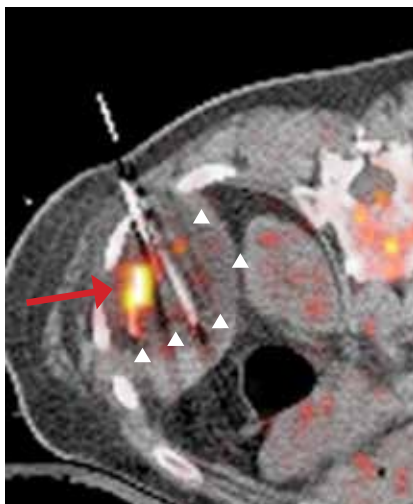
Fused PET/CT at the level of the upper cryoablation probe performed after initial cryoablation shows a hypo-intense region encompassing the tumor (white arrowheads), which represents the cryoablation ice ball. The area of uptake (red arrow) remains unchanged as compared to initial planning PET/CT since  $^{18}\text{F}$ -FDG does not dissipate from the tumor during or following cryoablation. Cryoablation freezes the tumor and adjacent tissues; the tracer within the tumor remains trapped, even after ablation. This helps confirm that the cryoablation ice ball, represented by the hypodense zone on CT extends beyond the  $^{18}\text{F}$ -FDG-avid tumor, thus ensuring adequate coverage of the tumor and a safety margin with cryoablation.
